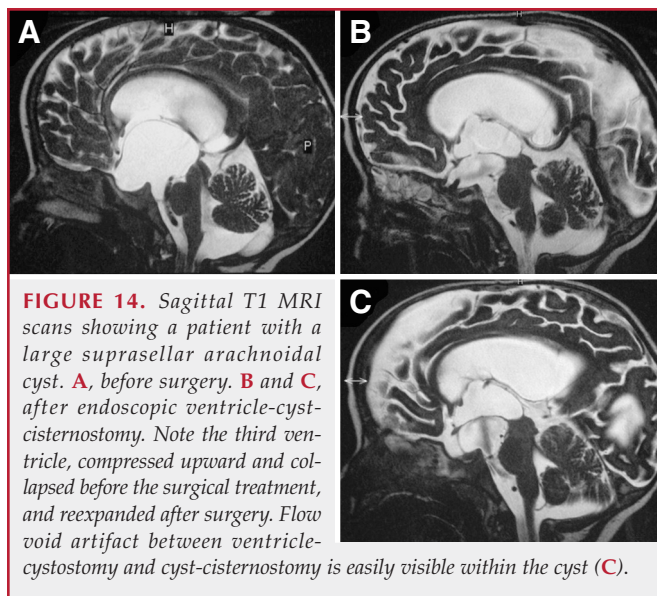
Sagittal T1 MRI scans showing a patient with a large suprasellar arachnoid cyst. A, before surgery. B and C, after endoscopic ventricle-cyst-cisternostomy. Note the third ventricle, compressed upward and collapsed before the surgical treatment, and reexpanded after surgery. Flow void artifact between ventricle-cystostomy and cyst-cisternostomy is easily visible within the cyst (C).
